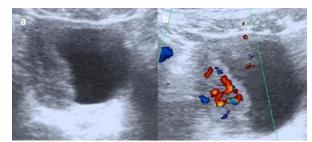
Right lateral bladder wall thickening in gray-scale ultrasound (a) and significant vascularization of the mass in Doppler USG (b) observed.
